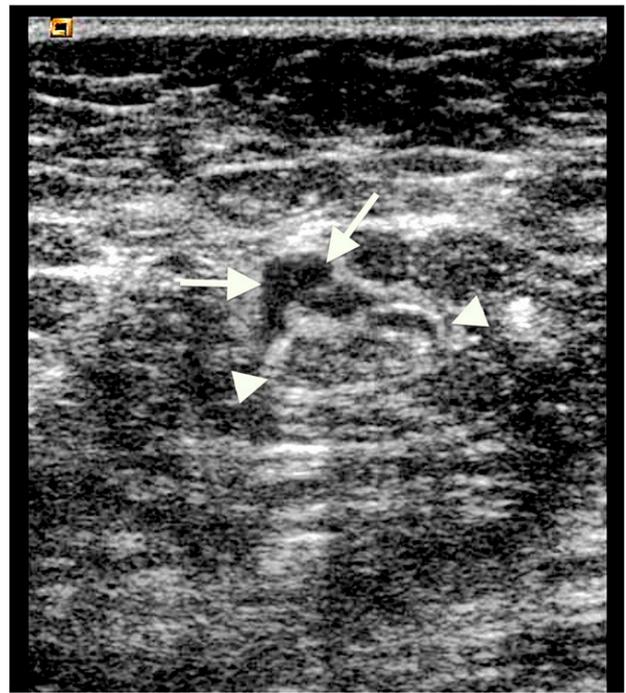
Early axillary lymph node metastasis. Sonogram shows a small but prominent bulge (arrows) at the periphery of an otherwise normal, fat-replaced level I axillary node (arrowheads).
